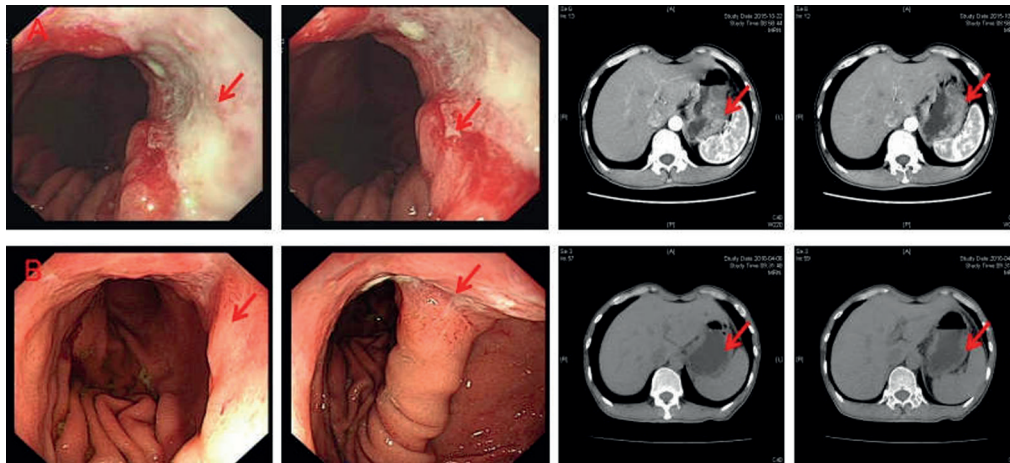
Typical case 2. Comparison of electron gastroscopy and CT images before (A) and after (B) intervention.
